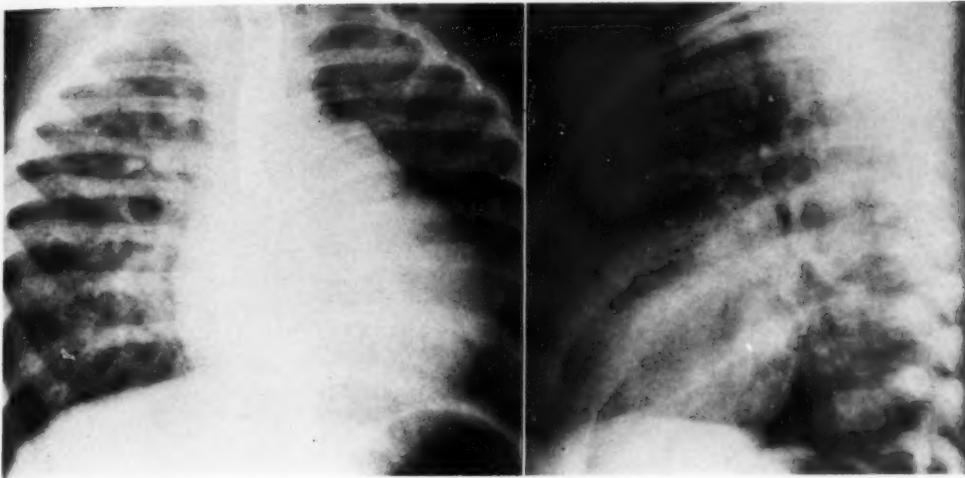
Roentgenograms of chest of cyanotic child of five and a half months. Right and left ventricular enlargement is evident. The pulmonary artery and its branches are also increased in size. Ductus measured 9 mm. in diameter.
